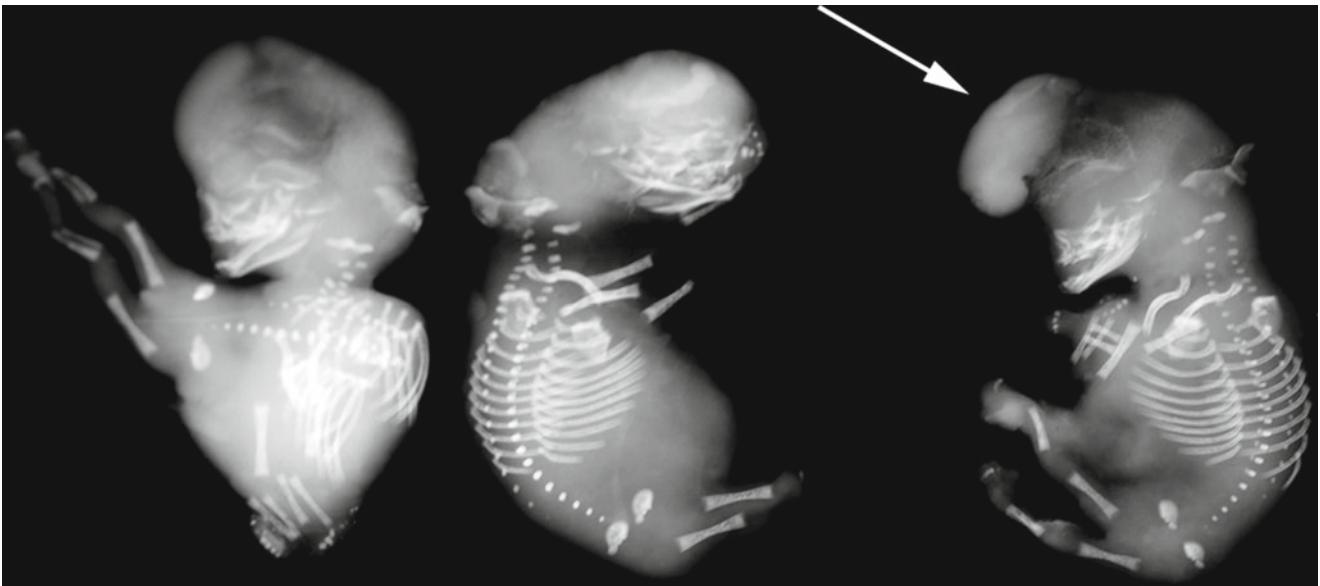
Triplet fetus papyracei from assisted reproductive technology (ART) gestation. The triplet at right has an encephalocele that was not recognized macroscopically. The radiograph shows the value to take x-ray pictures of such fetuses
